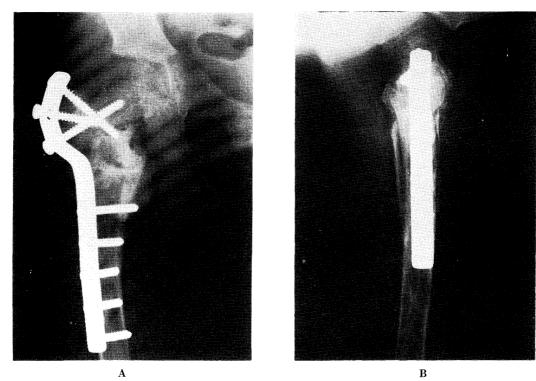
Radiograph demonstrate solid union between the fragments and allografts of bone (23, 9, 1984).
